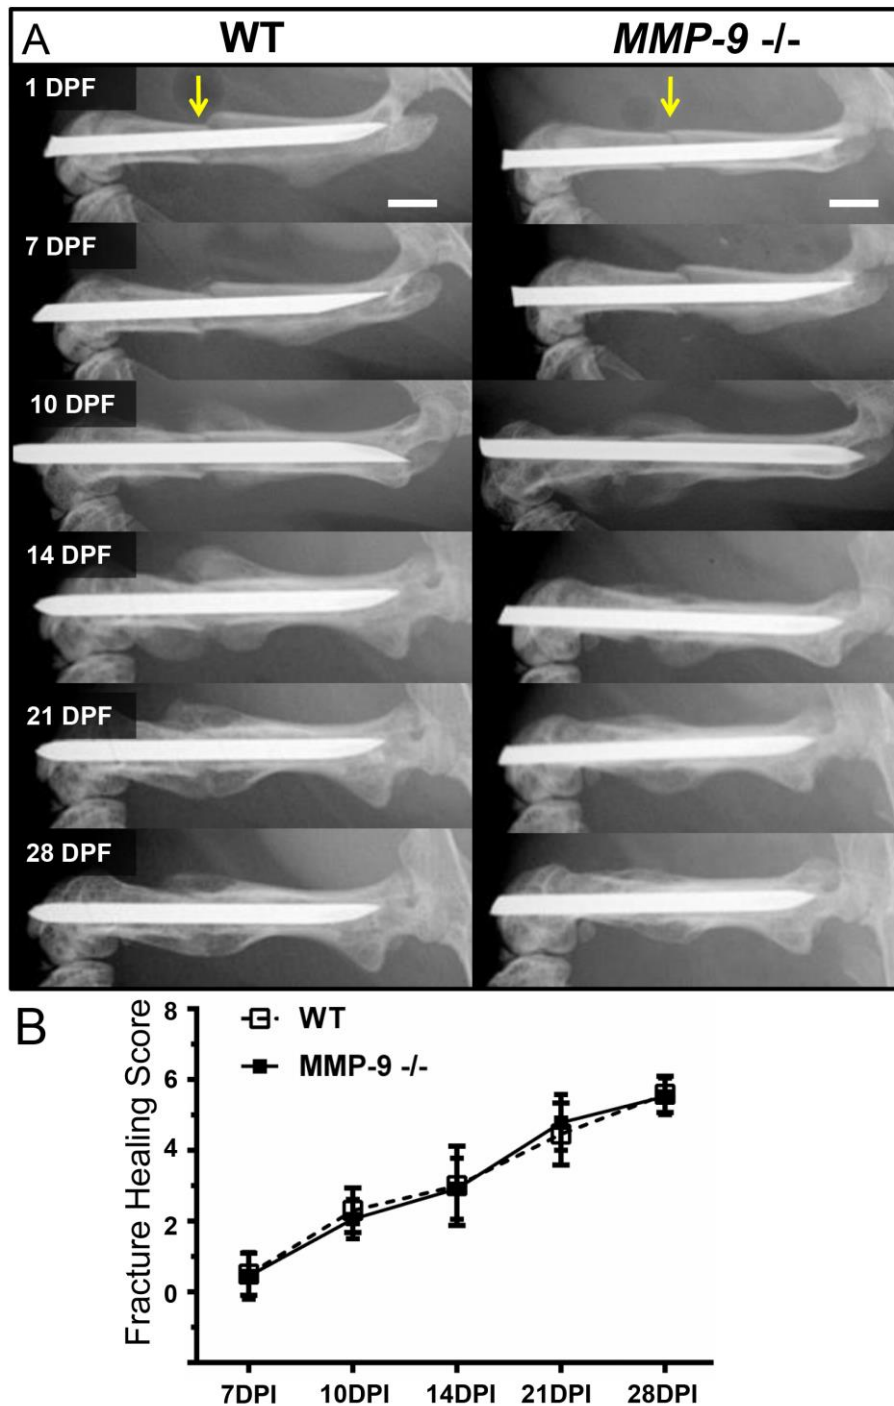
Radiographic Quantification of Fracture Healing. Fracture repair was quantified by three criteria: 1) bone formation, 2) bone union, and 3) bone remodeling. The anterior (area 1) and posterior (area 2) sides of the fracture callus were quantified
